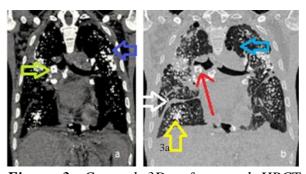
Coronal 3D reformatted HRCT images. 3a. mediastinal window shows multiple tiny calcified nodule in the bilateral upper lung fields (blue arrow) with calcified mediastinal and hilar lymph nodes (green arrow). 3b. Lung window shows multiple tiny calcified nodules in the bilateral lung fields
